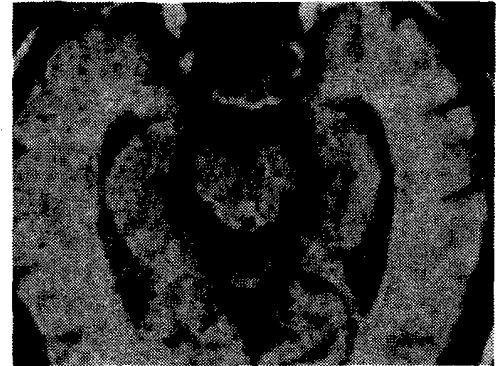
T1-weighted SE scan (TR 600, TE 40) in a patient with Alzheimer's disease shows large perimesencephalic cisterns and temporal horns, indicating medial temporal lobe atrophy.
